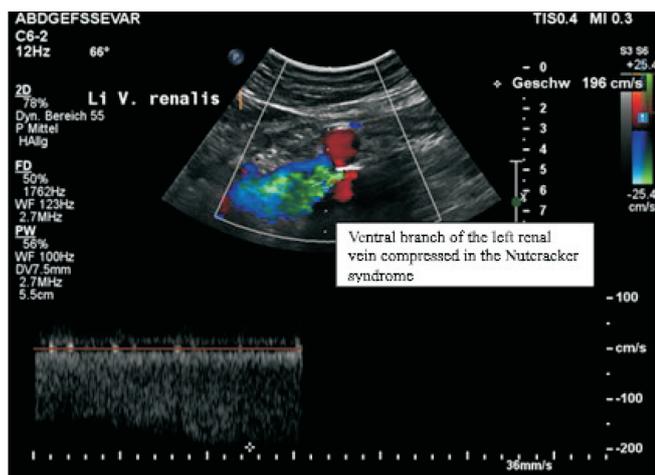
Nutcracker syndrome colour Doppler sonography of presented patient.
